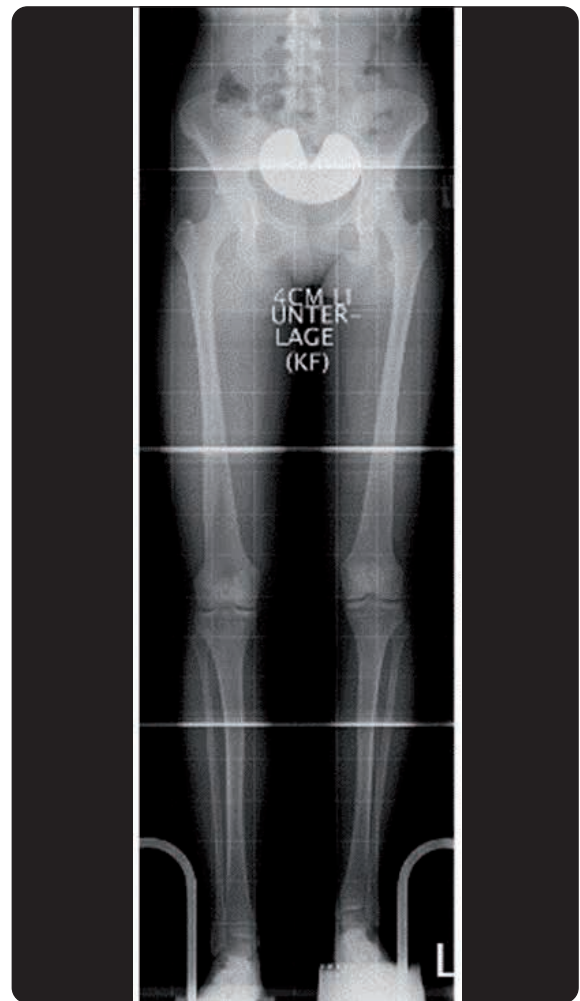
Long-standing X-ray
